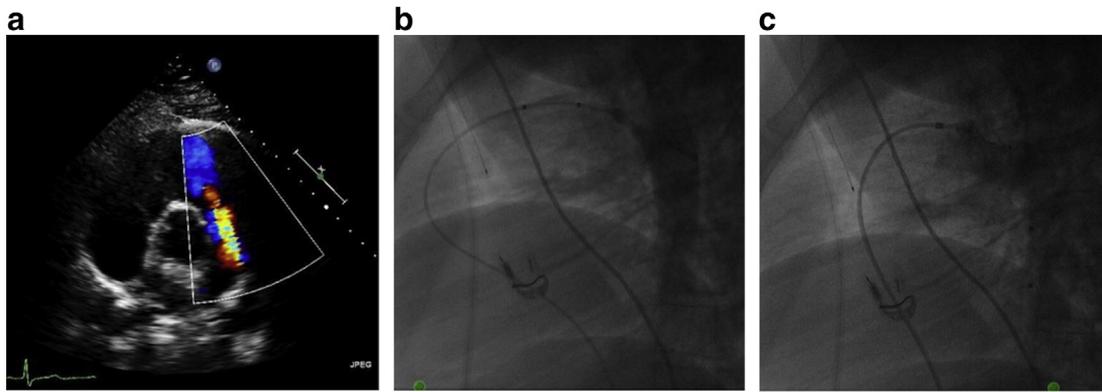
A: Trans-thoracic echocardiogram showing reversal of flow consistent with patent ductus arteriosus. B: Intraductal angiogram showing saccular Type D ductus. C: Post-deployment angiography showing complete occlusion of ductus.
